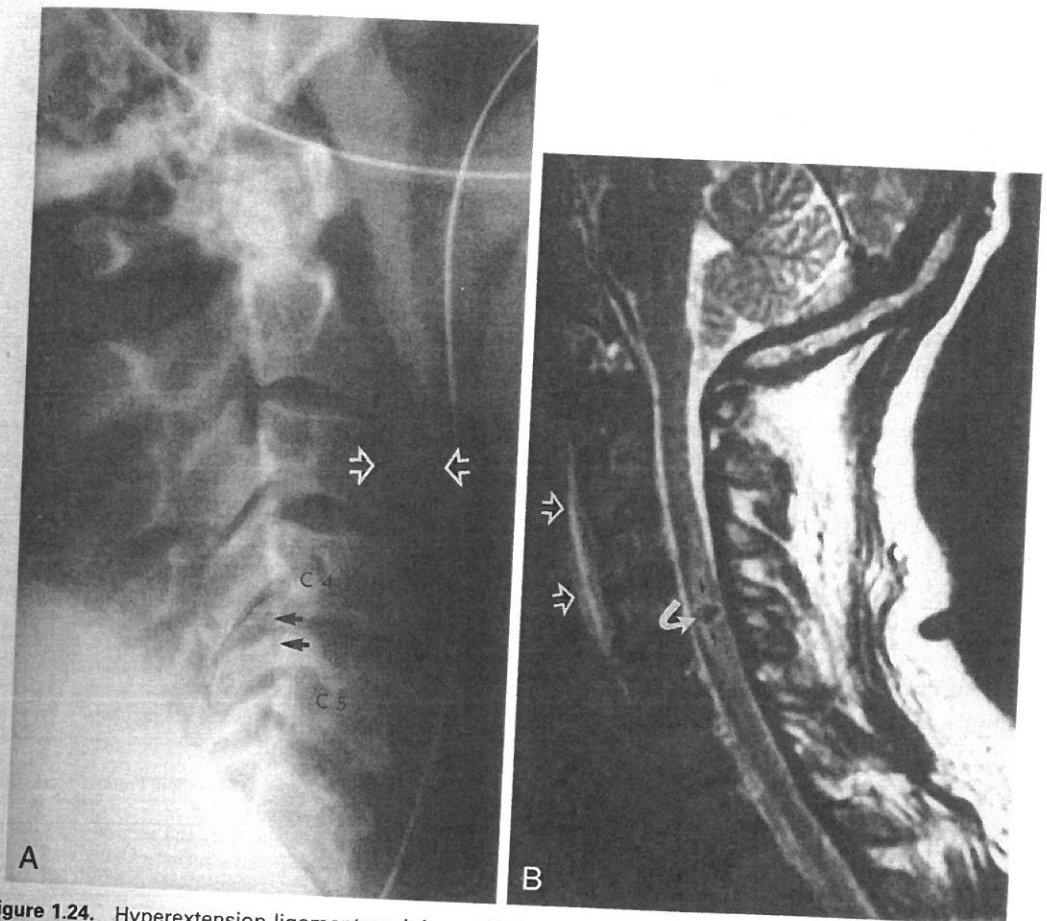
Hyperextension ligamentous injury with hemorrhagic cord contusion in a 39-year-old male involved in a motor vehicle accident. *A*, lateral view of the cervical spine shows subtle retrolisthesis at C4-C5 (solid arrow). *B*, sagittal MR T2-weighted (TR 2100, TE 112) shows bulbus enlargement of the cervical cord, centered at C4-C5, related to a broad area of cervical contusion manifested as high signal (white arrows). Focal area of low signal (curved arrow) indicates subacute hemorrhage and qualifies the cord contusion as a hemorrhagic contusion, which has a more ominous prognosis. Associated prevertebral hematoma shows high signal (open arrows).
